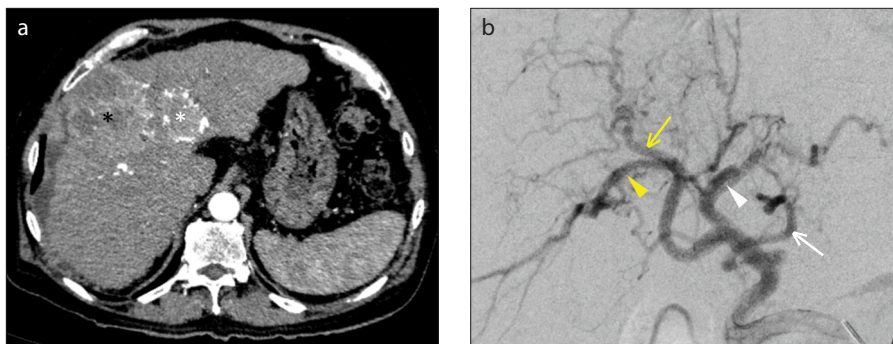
a, b. Axial CT in arterial phase through the liver (a) shows cirrhosis, a large centrally placed hepatocellular carcinoma (black asterisk) and a smaller carcinoma nodule (white asterisk) to the left of it. Digital subtraction angiography of the common hepatic artery (b) shows diffusely tortuous hepatic artery branches. Left hepatic arterial branch arising from the proper hepatic artery (white arrow), left hepatic artery (white arrowhead), anterior (yellow arrow) and posterior (yellow arrowhead) branches of the right hepatic artery are shown.
